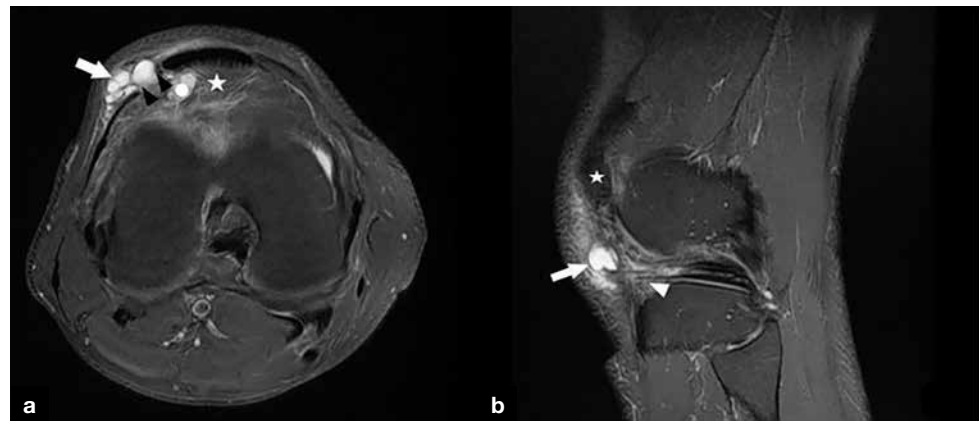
a. Coronal and (b) sagittal magnetic resonance images. White arrow: subcutaneous cyst; white arrowhead: infrapatellar cyst; white star: patella; black arrowheads: patellar retinaculum defect.
